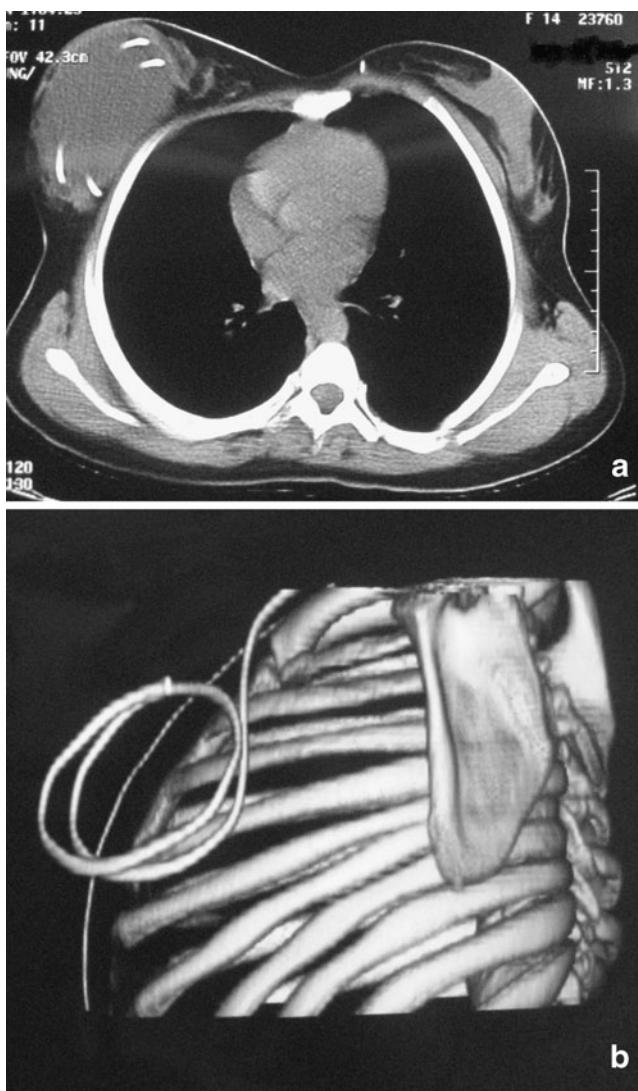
a Chest CT scan in axial view shows breast asymmetry and the pseudocyst lateral of the breast containing loops of catheter. b Three-dimensional CT scan of chest confirms the distal tube migration and coiling
